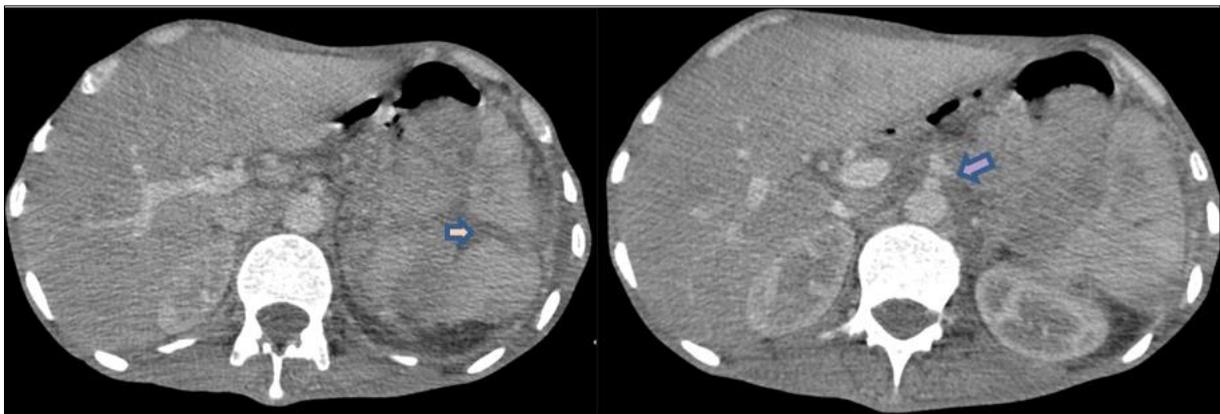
Abdominal CT with contrast done 6month previous:
